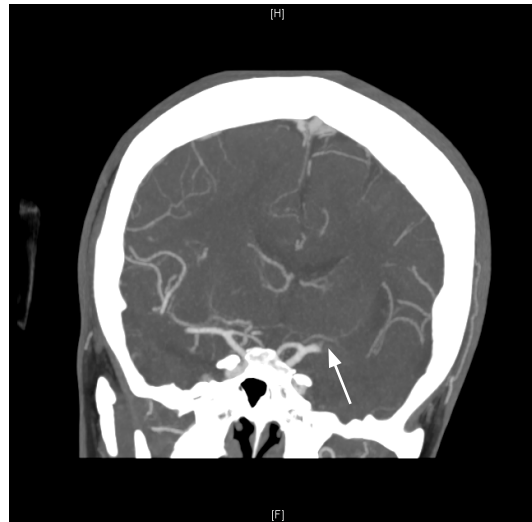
Computed Tomography Angiogram showing occlusion of proximal M1 segment of the left middle cerebral artery (arrow)
